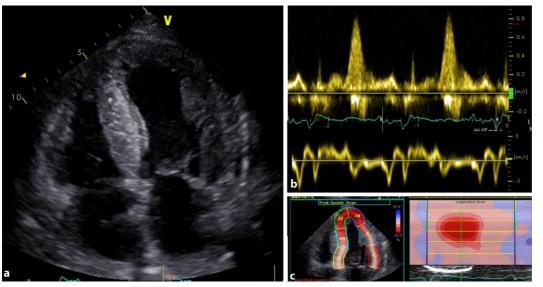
< Typical echocardiography features in cardiac amyloidosis patients. a Thickened LV wall, biatrial dilation, thickening of atrioventricular valves in apical 4-chamber view. b Doppler interrogation demonstrates a restrictive filling pattern in the mitral inflow study with high LV filling pressure (Calculation of E/e' is estimated to >15). c A representative bull's eye plot of longitudinal strain. Note that the longitudinal strain of the apex is preserved in contrast to those of the other midventricular or basal segments
